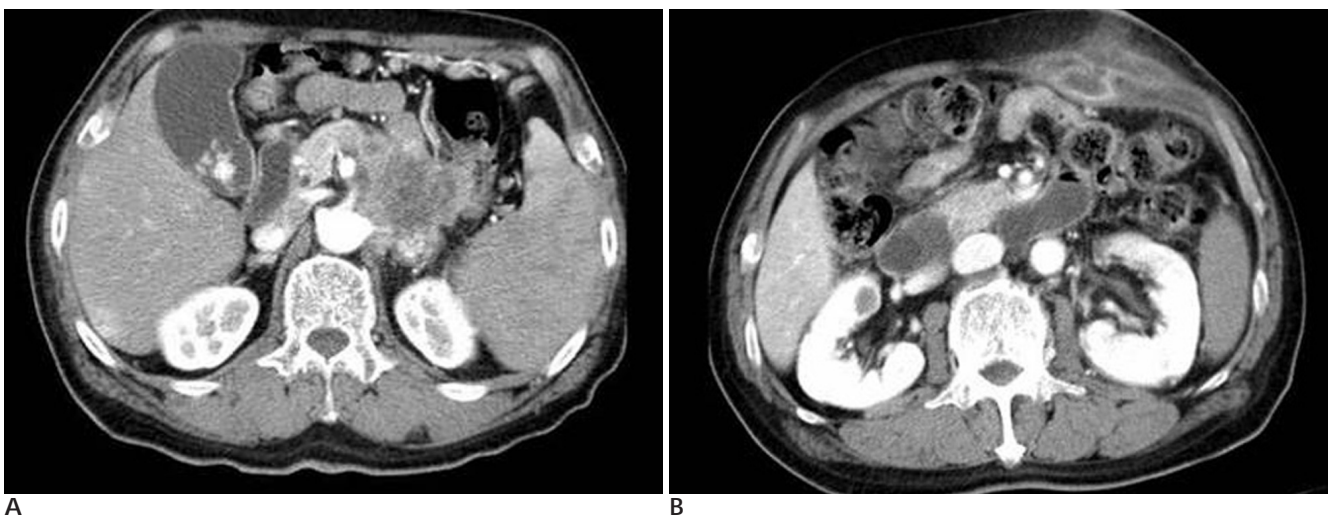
Abdominal CT scan of a 75-year-old man with needle tract implantation from adenosquamous carcinoma of the pancreatic tail.
